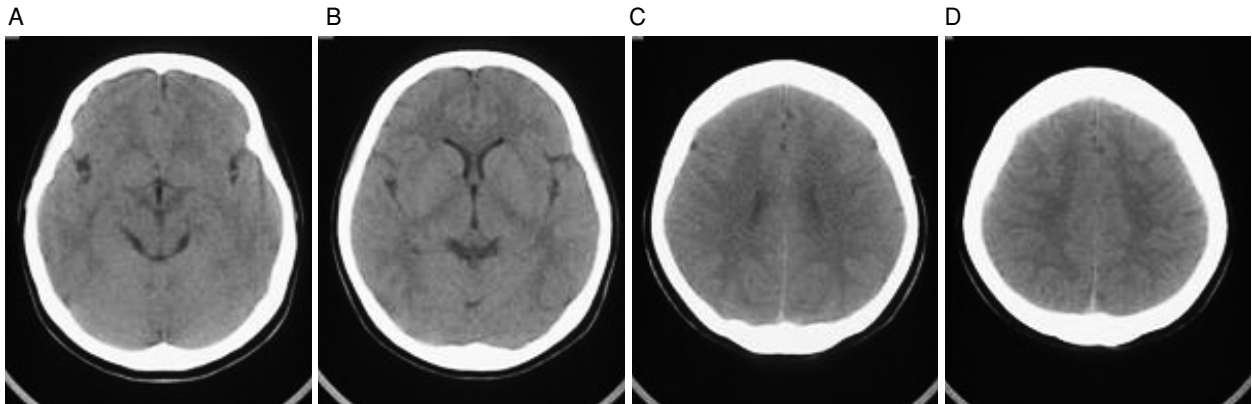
Computed tomography scans (A–D) at the onset of migraine
